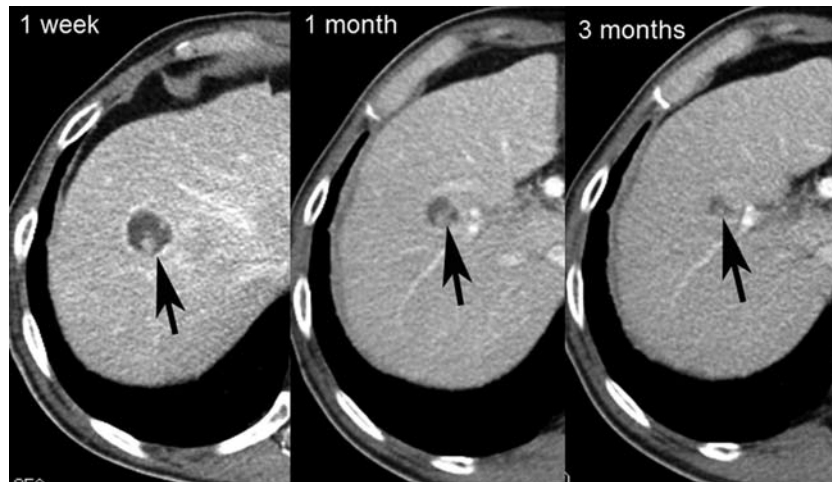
Follow-up CT 1 week, 1 month, and 3 months after bland TAE show the shrinkage of the tumor (arrows).
